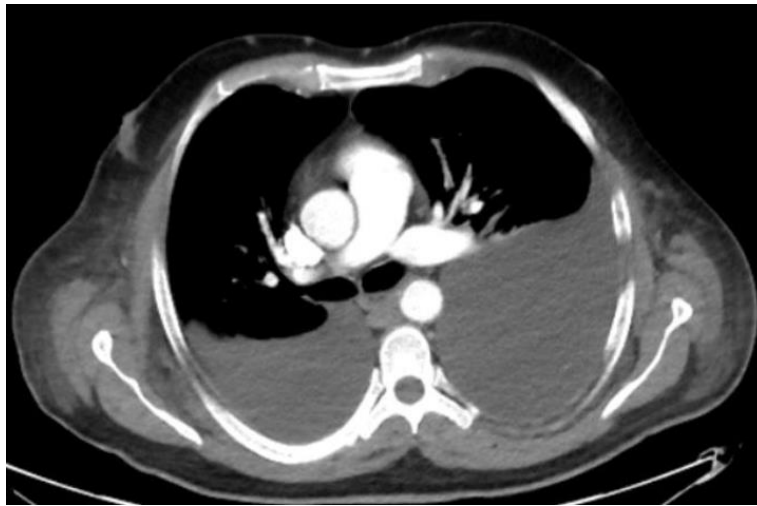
Contrast-enhanced thoracic CT scan showing bilateral pleural effusions, predominantly on the left side.
